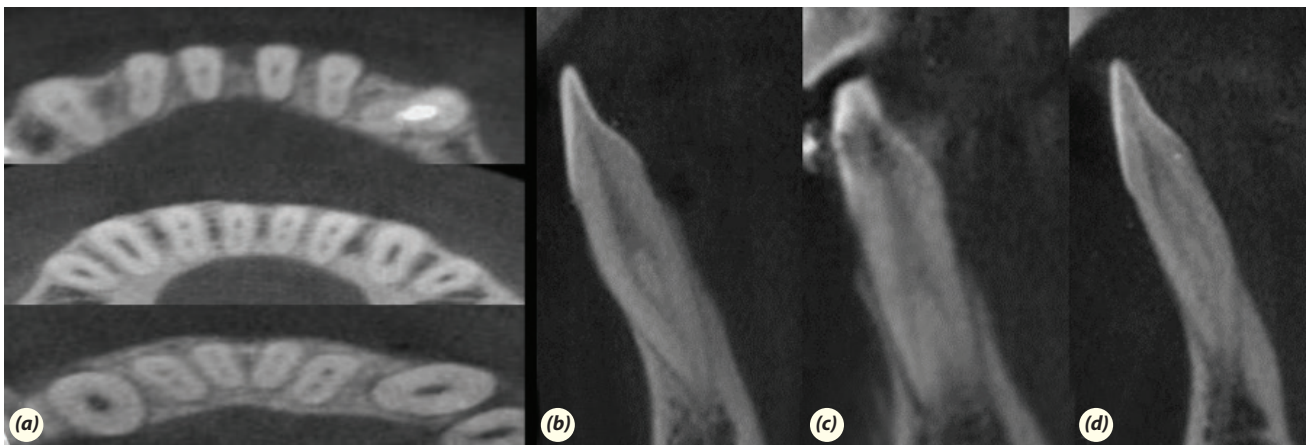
Axial CBCT views of mandibular incisors with two canals (a). Sagittal CBCT views of mandibular incisors with root canal morphology of Vertucci type III (b), type V (c), and type VI (d).
